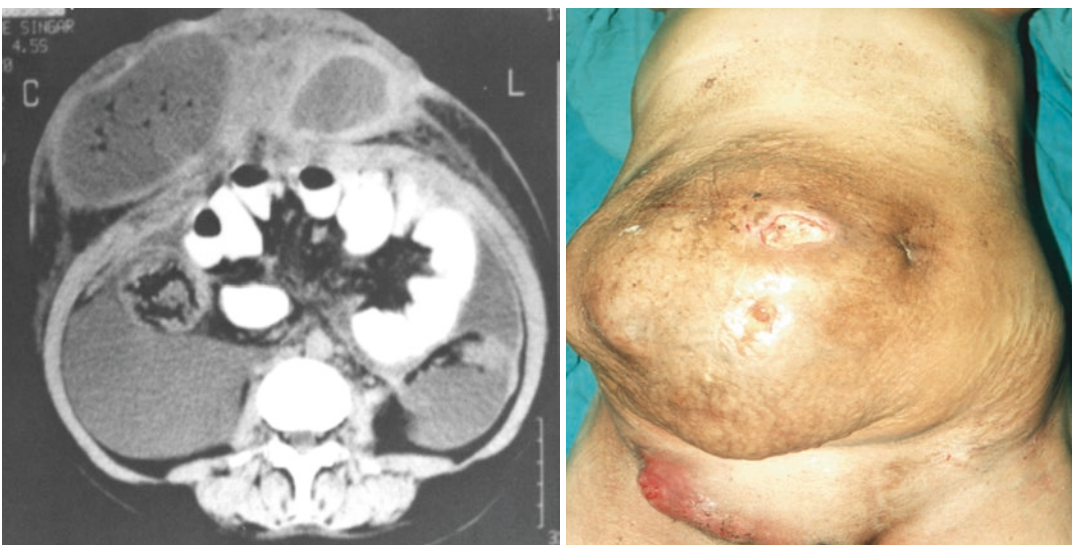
CT view of omental strangulation and necrosis findings in our patient who underwent laparotomy due to strangulated incisional hernia and right femoral hernia
